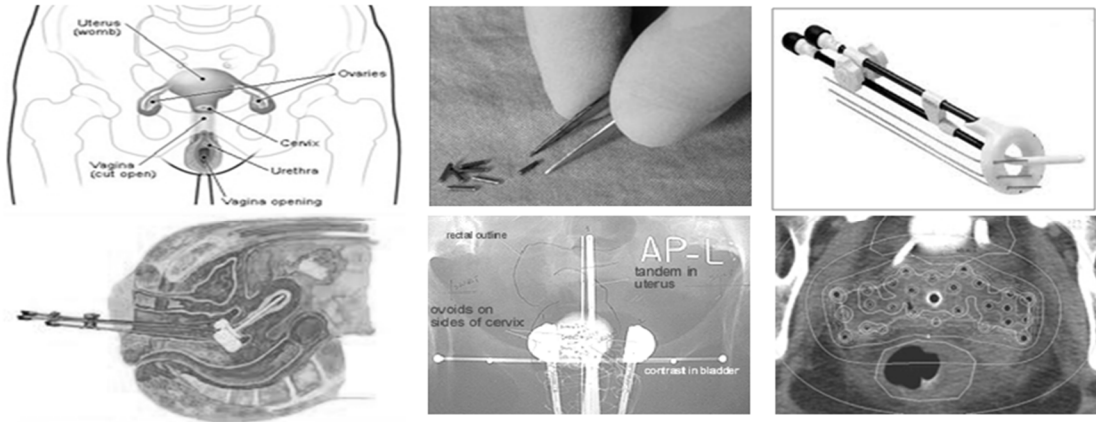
On the far left, we show the cervix anatomy (top) and the associated HDR treatment with the applicator (bottom). The remaining images on the top show the Ir^{192} radioactive seeds and the Vienna ring CT-MR applicator. The CT image (bottom middle) shows the catheters and seed positions with respect to the diseased cervix. The image is used for treatment-planning optimization. The bottom right shows a transverse view with isodose curves overlaid.
